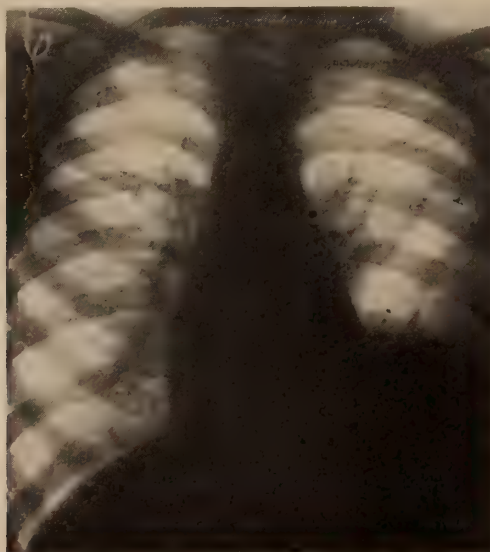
After a period of observation for two years, the shadow in the left thorax cleared, but x-ray examination still revealed some pathology at the left base.
